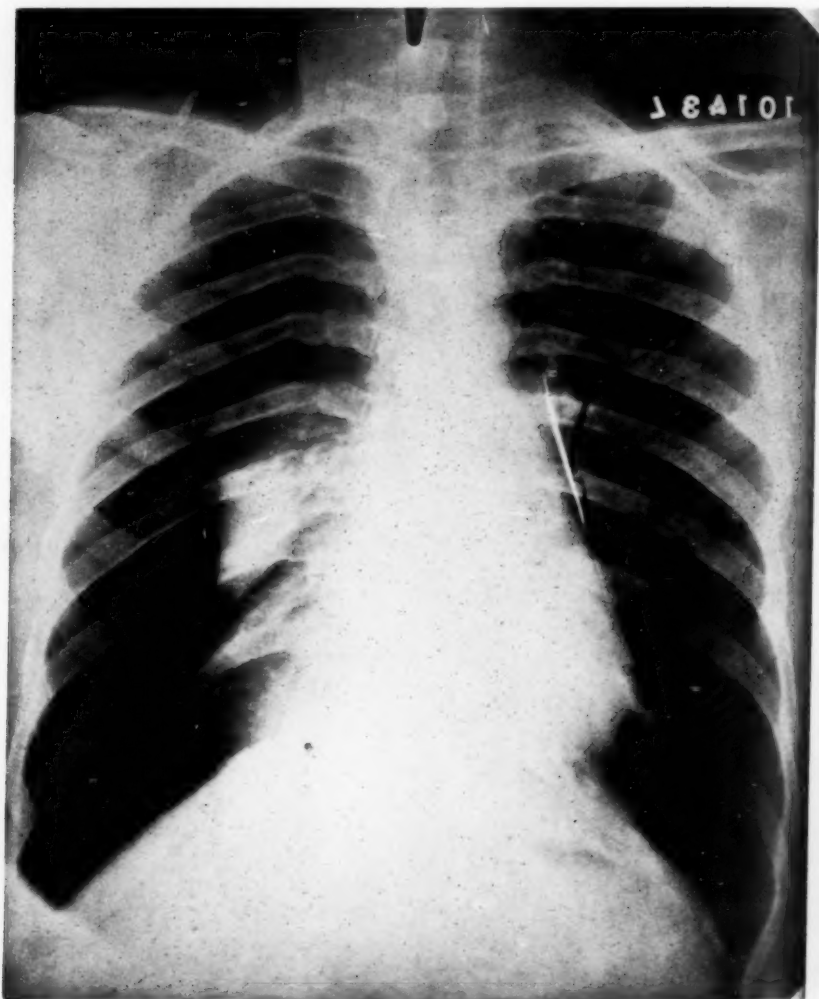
Radiograph of case No. III at time of pneumothorax.
